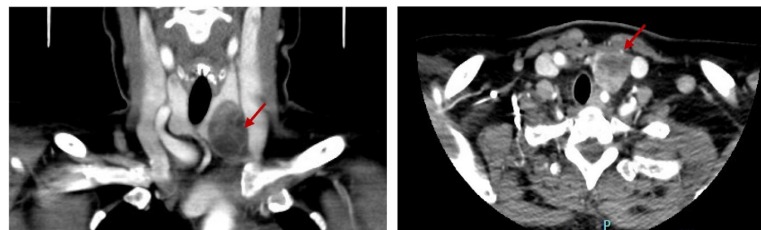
4D neck CT demonstrated a heterogeneously enhancing nodule arising within the inferior aspect of the left lobe of the thyroid suggestive of an intrathyroidal parathyroid adenoma.
